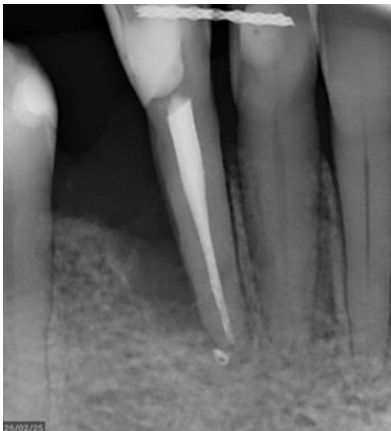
Initial periapical radiograph showing a vertical bone defect distal to tooth 42.
